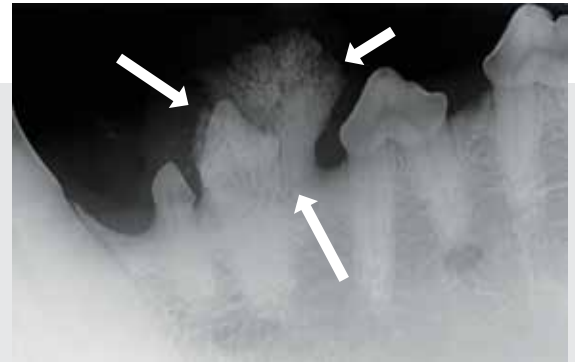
Radiographic appearance of an ossifying peripheral odontogenic fibroma at the left mandibular second premolar (306) (white arrows). Note the proliferative bone but lack of bone lysis.
